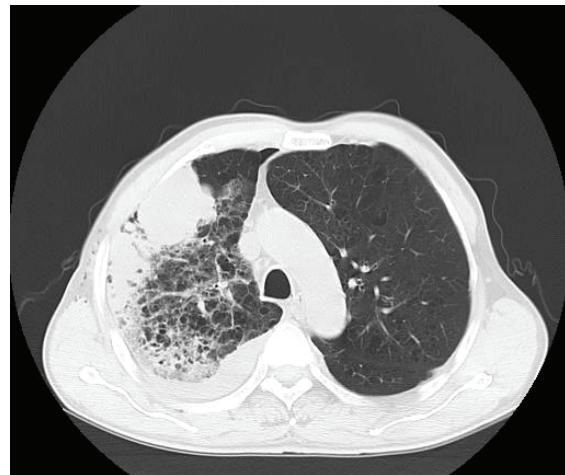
Chest Routine Scan and CT examination of the patient. A consolidation area in the basal segments of lower lobe of left lung with lobe atrophy was found in it. The diagnosis is doubted for the periphery lung cancer. The CT result showed there was no tumor in other part of the body.
